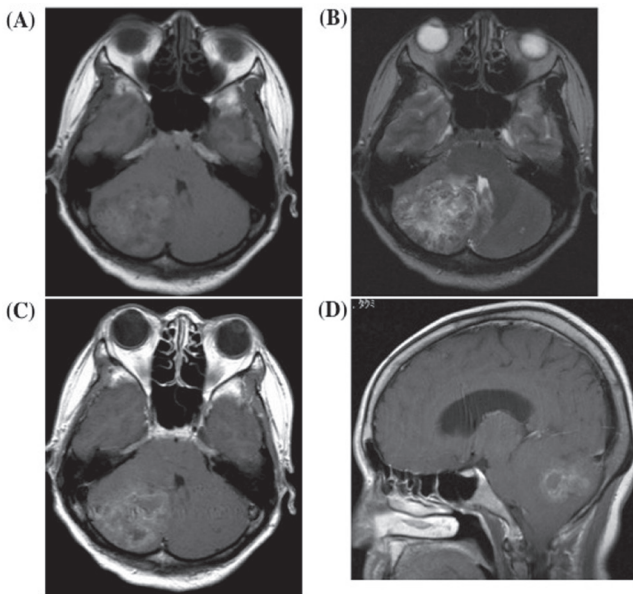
Preoperative magnetic resonance imaging (MRI) showing a lesion in the right cerebellar hemisphere that was isointense on T_1 -weighted imaging (A) and that was hyperintense on T_2 -weighted imaging (B). The tumor was heterogeneously enhanced with gadolinium on axial (C) and sagittal images (D). Note the tonsillar herniation causing, compression of the brainstem and obstructive hydrocephalus.
